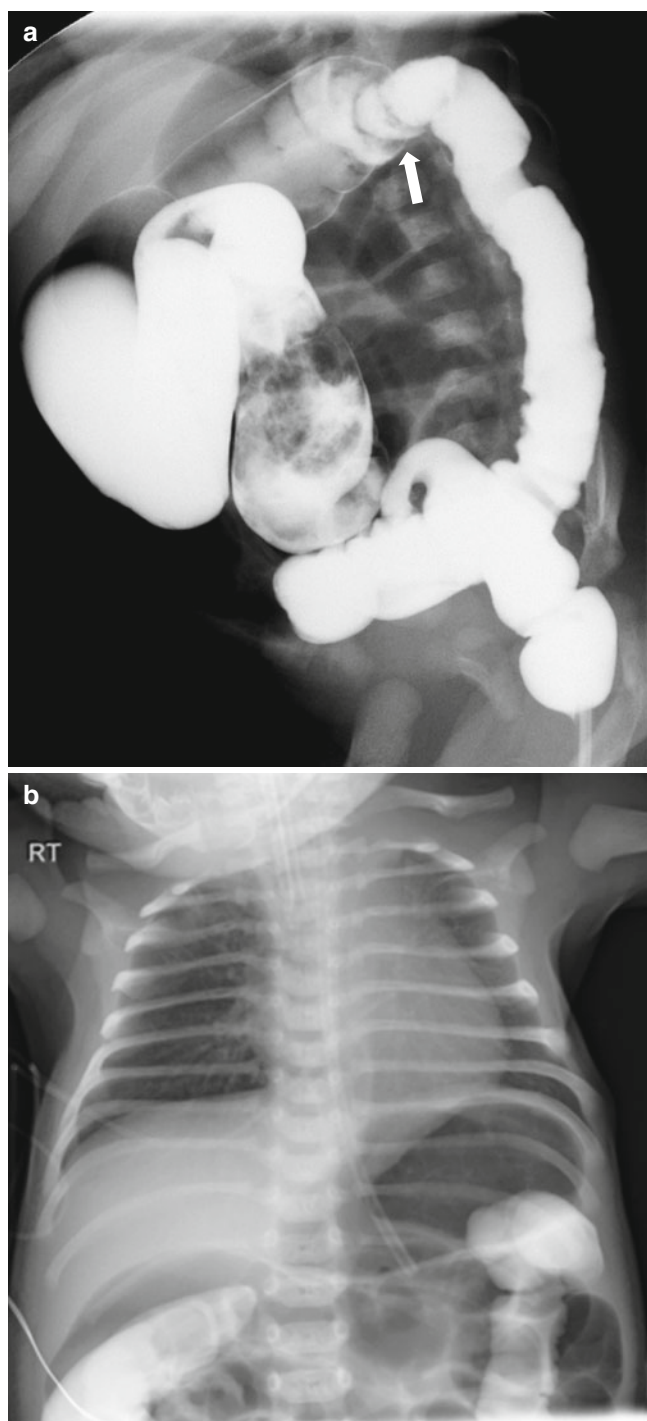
Hirschsprung disease in a 3-day-old newborn presented with abdominal distension and apnea. (a) Oblique view of barium enema shows transition zone at the splenic flexure (arrows) and relatively decreased caliber of the long segmental aganglionic distal colon with irregular contour. (b) This baby was intubated due to central hypoventilation, and a chest radiograph several days after a barium enema shows retention of contrast in the colon as well as small-bowel dilatation. Diagnosis of Haddad syndrome was made based on biopsy confirmed aganglionosis and central hypoventilation
